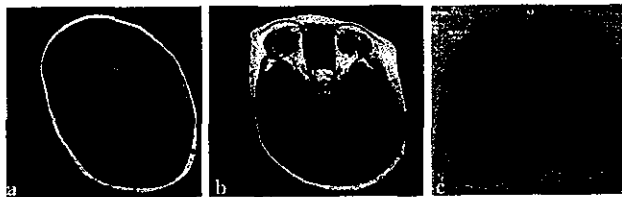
Brain MRI of patient at age 3 years shows agyria frontal and temporo-occipital lobes mixed with pachygyria parietal cortex, hypoplasia of brain stem and cerebellum, and defect of septum pellucidum. The periventricular white matter change (A and B, TR540/TE15; C, TR5400/TE90) also is seen.
